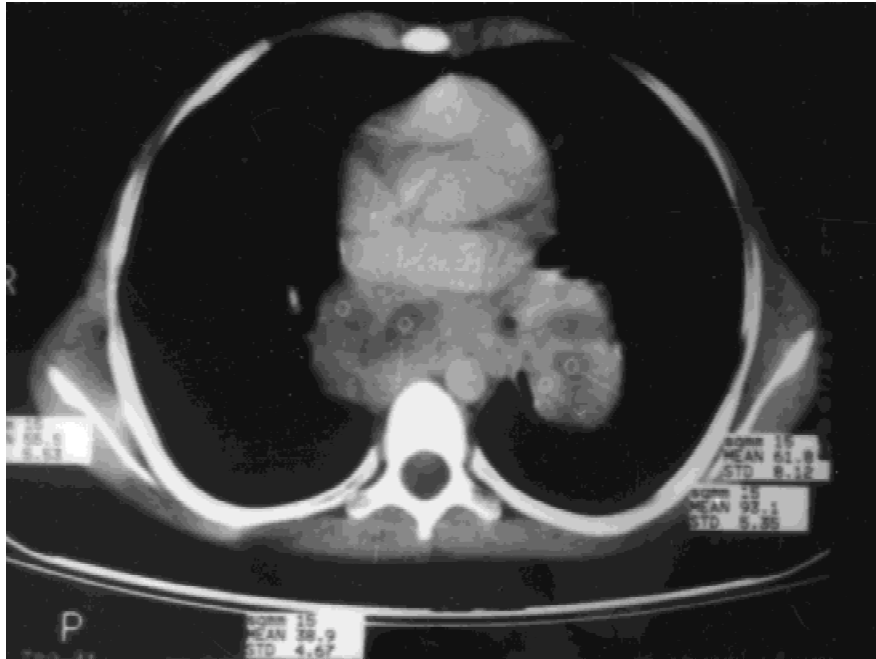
A CT scan showing lymphadenopathy in the right paratracheal, pre- and sub-carinal, posterior mediastinal and left hilar areas, compressing the left pulmonary artery and bronchus.
